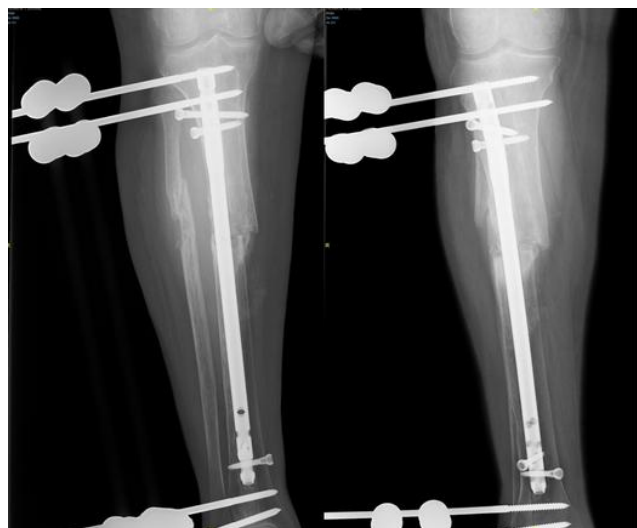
X-Ray 8 Weeks After Second Surgery.
